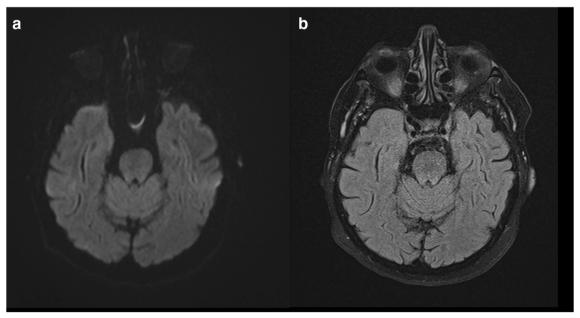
Brain MR after 7 days showing DWI (a) and FLAIR (b) signal abnormalities disappearance
